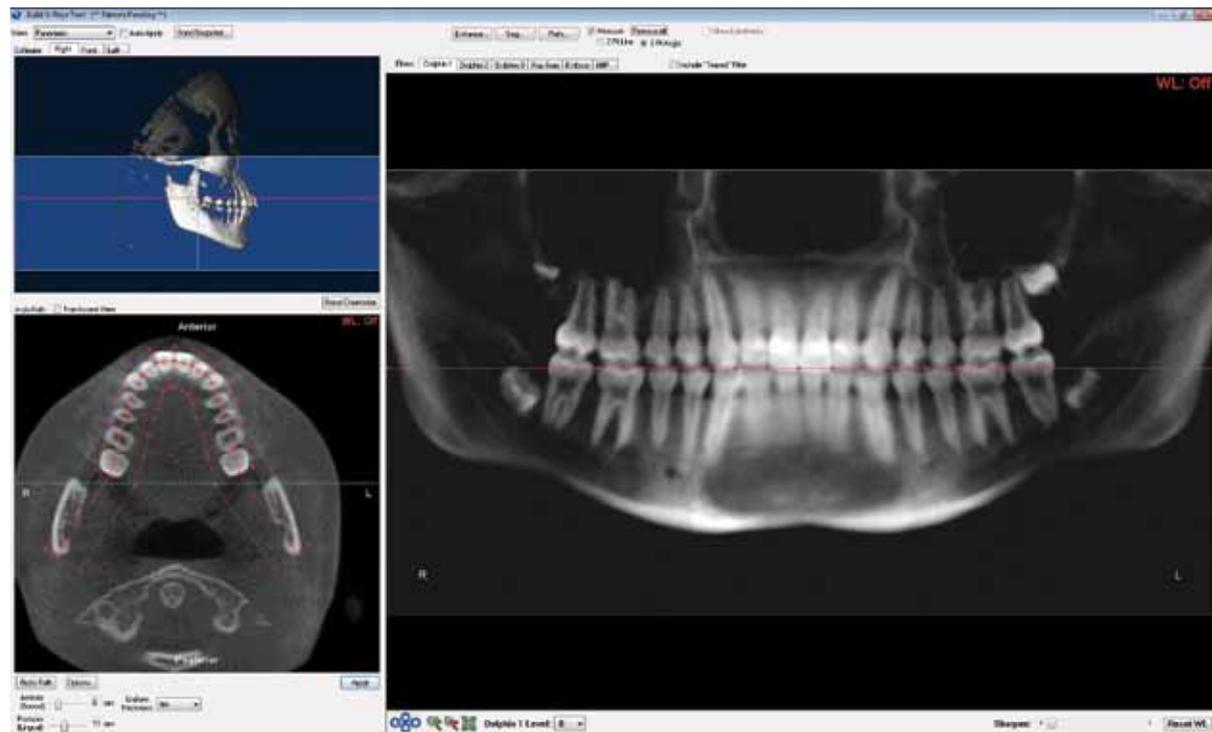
Constructing a 2-D panoramic-like image from a 3-D CBCT patient scan. Photos/Provided by Ammar Siddiqi and Nicole Sakai, DDS
